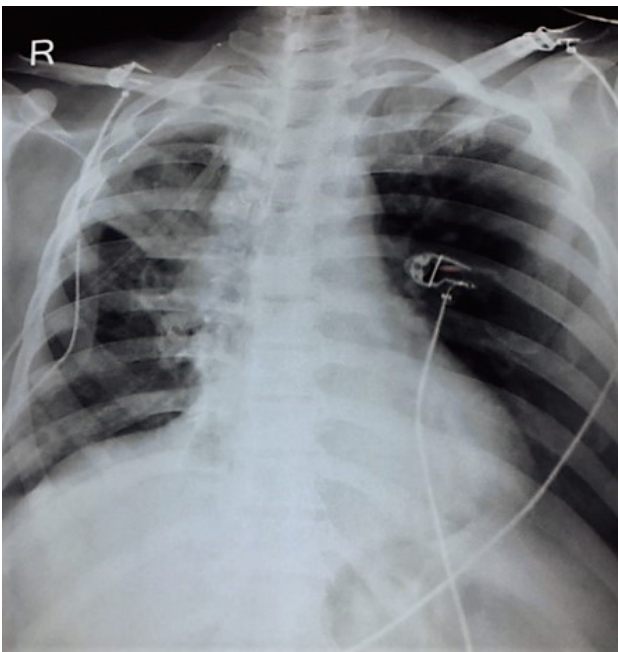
X-ray of the patient with right side ICD in-situ with lung expansion
